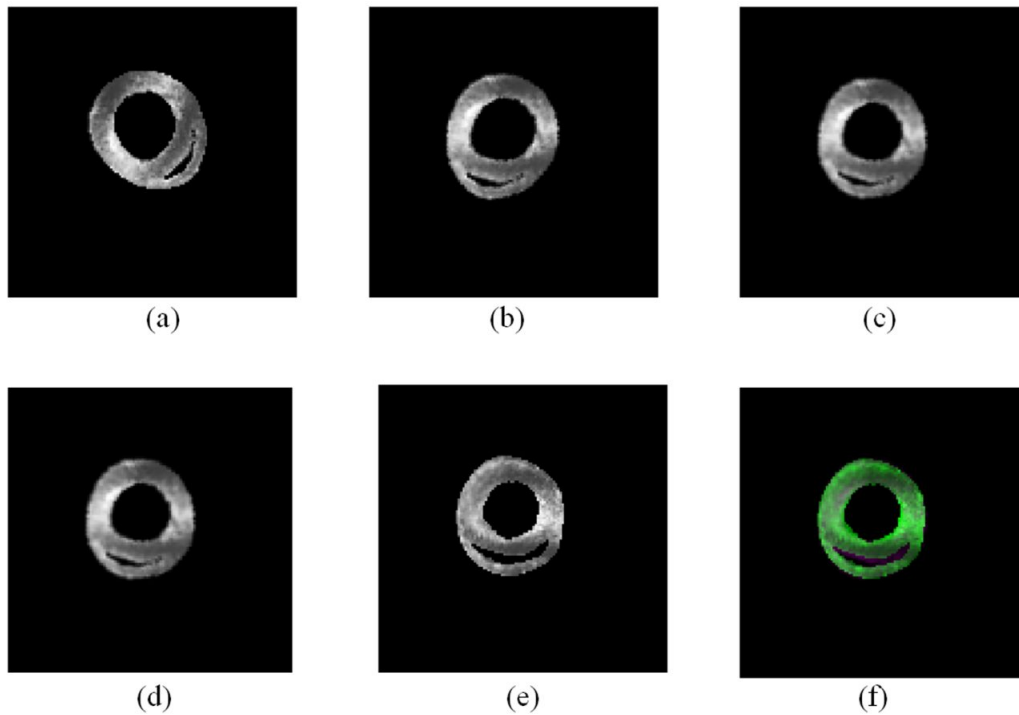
Example results of the image registration and inverse transformations. (a) Input 2D ultrasound image. (b) Result of the 2D image after rigid registration slice by slice from the 3D template volume. (c) Result after log-demons registration. (d) Result after affine registration inversely. (e) Corresponding slice in the volume. (f) Fusion of (d) and (e).
